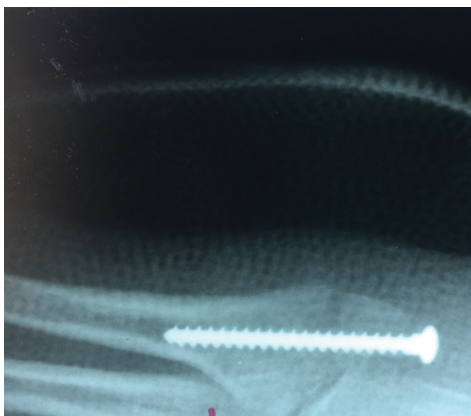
A post-operative radiograph of a 19 year old male runner who had an inversion sprain of the ankle that was untreated and failed to get better with 4 weeks of rest and OWB. An x-ray taken at a hospital ER showed an avulsion fracture of the styloid process with a significant gap at the fracture site (4-5 mm.). Because of the lag in treatment and the significant treatment gap, surgery was suggested. The x-ray above was taken 3 days post-operatively and showed good reduction of the avulsion. The patient followed a 2-week OWB, 2 week SWB, and 2 week FWB protocol and returned to running at about 8 weeks. The screw fixation was left in place.
